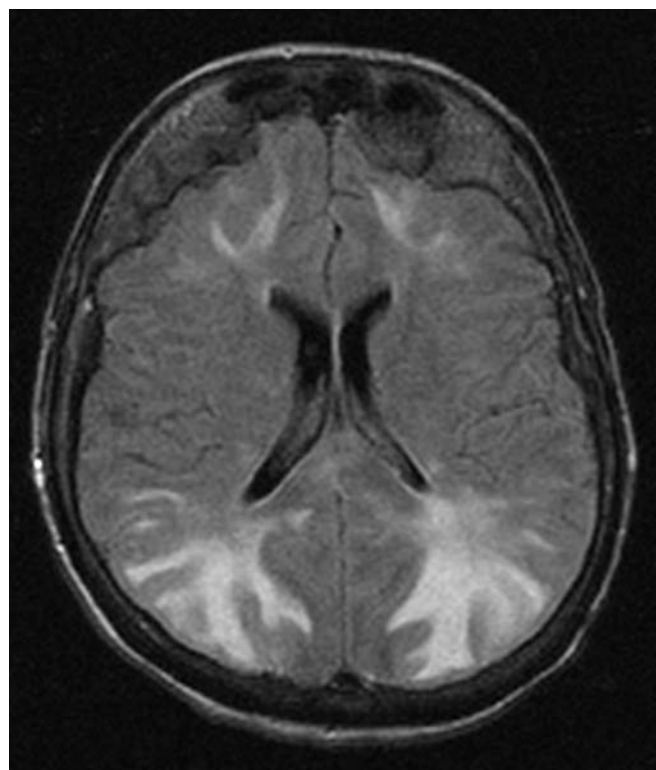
Axial fluid-attenuated inversion recovery MRI showing white matter hyperintensity in the occipital lobes bilaterally consistent with posterior reversible encephalopathy syndrome. The patient's confusion improved with blood pressure control. Repeat MRI after several days of therapy demonstrated remarkable improvement. [Image used with permission of Michael Farner, MD.]
